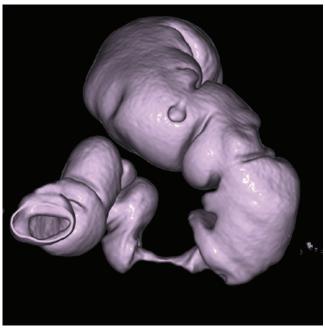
Shaded surface image obtained during virtual colonoscopy reconstructed from a 64-slice spiral computed tomography data set. (Courtesy Lance Blackwell, TeraRecon, Inc.)
